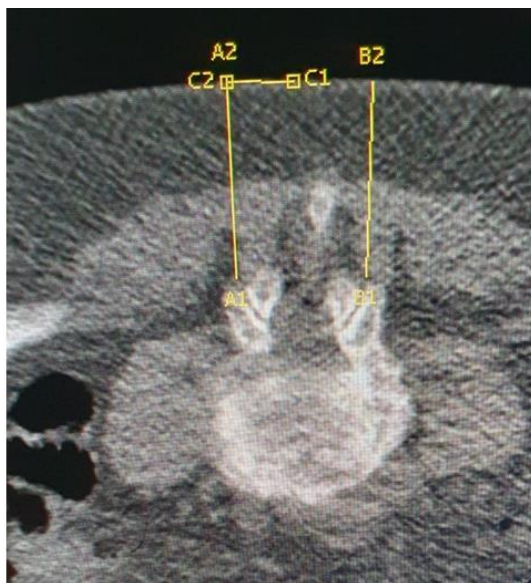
Preliminary CT scan prior to treatment.
